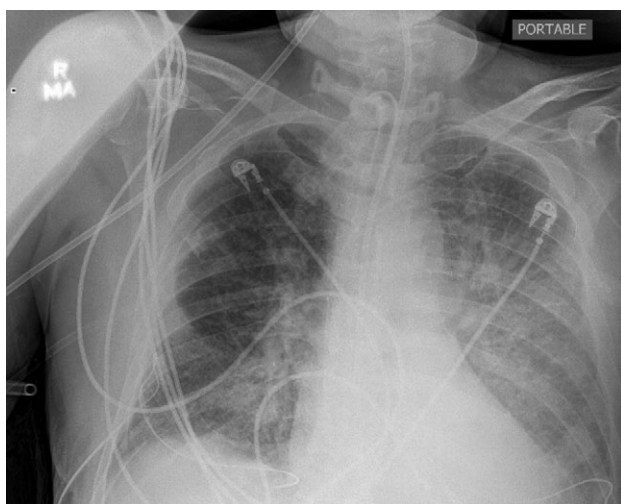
Chest X-ray: diffuse bilateral interstitial and airspace opacities on the left greater than the right with an interval increase in size of the left lower lobe infiltrate
